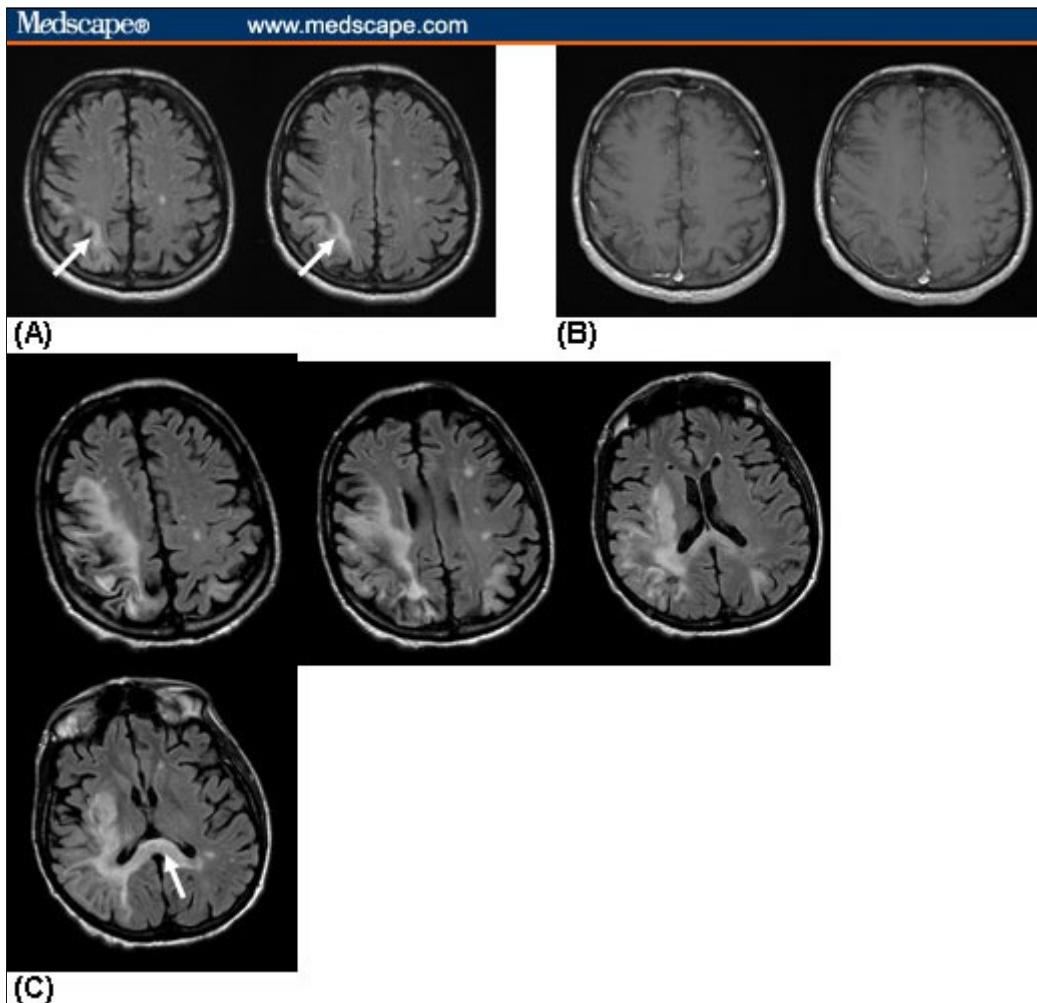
MRI images depicting PML. (A) FLAIR and (B) gadolinium-enhanced scans at presentation of behavior change and clumsy left hand demonstrate multifocal T2 abnormalities that do not enhance, including 1 confluent subcortical hyperintense lesion in the high right parietal region. (C) FLAIR images from 4 months later demonstrate profound enlargement of initial lesions, appearance of new lesions, and spread across the corpus callosum (arrow). Again, no lesions enhanced with gadolinium.
